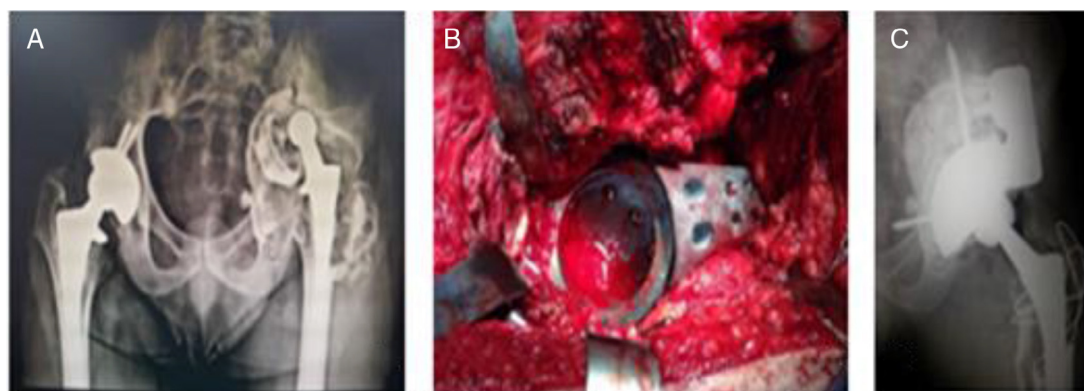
Total left hip arthroplasty revision with acetabular reconstruction. A, preoperative radiograph showing severe acetabular defect on the left (Paprosky 3B); B, perioperative imaging showing the use of chock-shaped column support trabecular metal wedge; C, panoramic postoperative radiograph of the pelvis.
